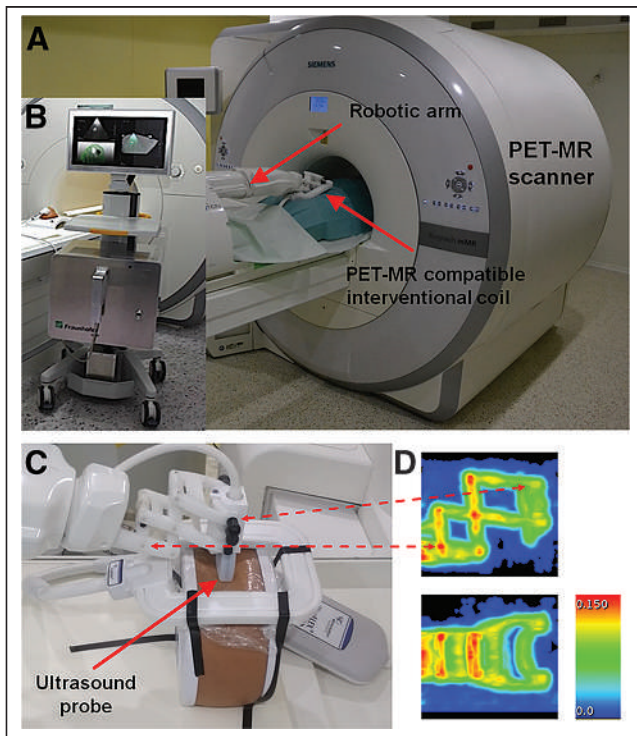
Integration of Innomotion robotic arm (InnoMedic GmbH) into Biograph mMR PET/MRI scanner (Siemens Healthineers). (A) Robotic arm was modified to fit into PET/MRI system holding ultrasound imaging probe. (B) MRI-compatible FUS system Diphas (Fraunhofer IBMT) can be integrated into PET/MRI scanner. (C) Three-dimensionally printed adaptor and fixation parts were manufactured to hold ultrasound transducer. (D) Attenuation map of robotic arm visualized by 2 perpendicular maximum-intensity projections of PET annihilation photons (in 1/cm) with linear attenuation coefficient of 511 keV, obtained by stand-alone PET scanner equipped with $^{68}\text{Ge}/^{68}\text{Ga}$ rod sources.
